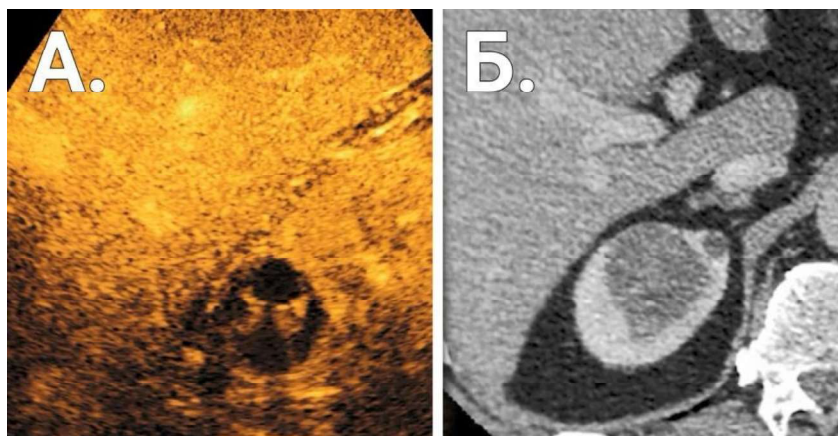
Large cyst in the upper pole of the right kidney with computed tomography with contrast and echo contrast ultrasound. A -during echo contrasting, the internal cystic septations are well differentiated. B - with computed tomography there is no visualization of internal cystic septations.
